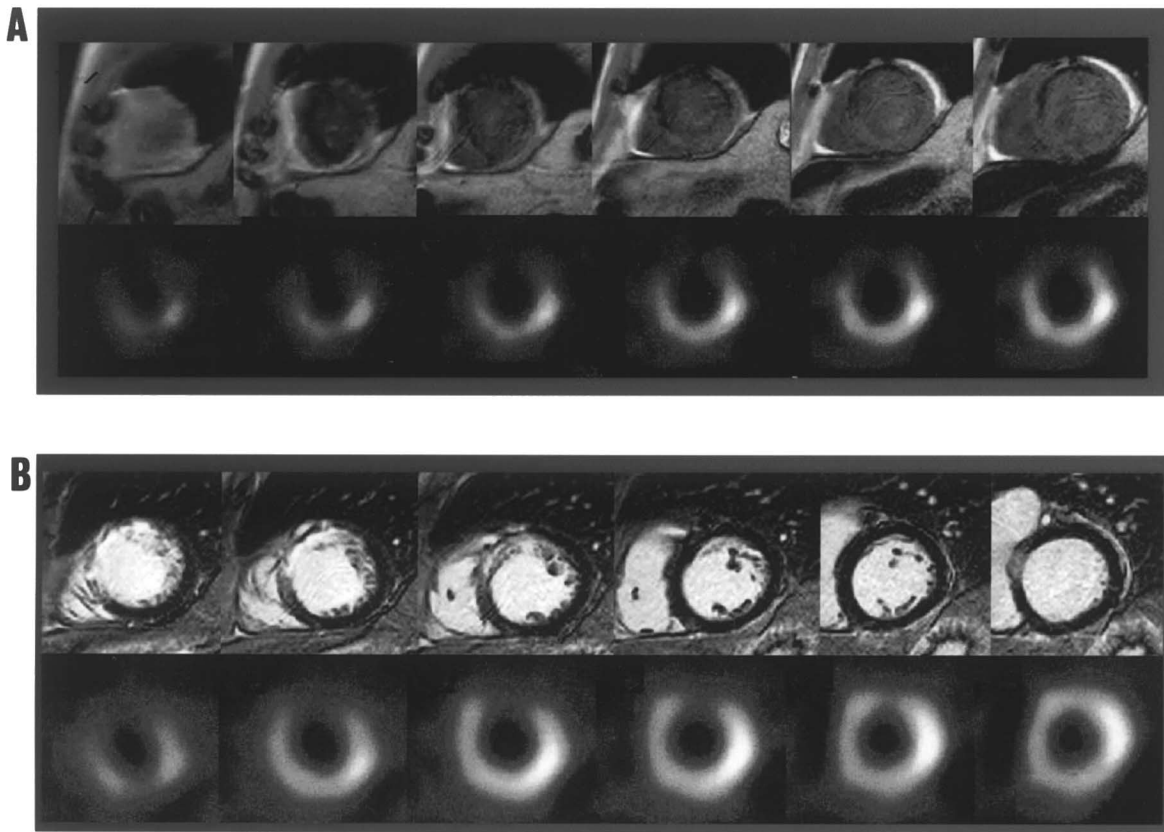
(A) Cellular cardiomyoplasty associated with the implantation of a cell-seeded matrix. MRI-SPECT studies at baseline showing a LV myocardial infarct extension of 64% (11/17 segments). (B) MRI-SPECT at 1 year follow-up, showing the reduction of the pathological area, now the myocardial infarct extension is of 41% (7/17 segments).
